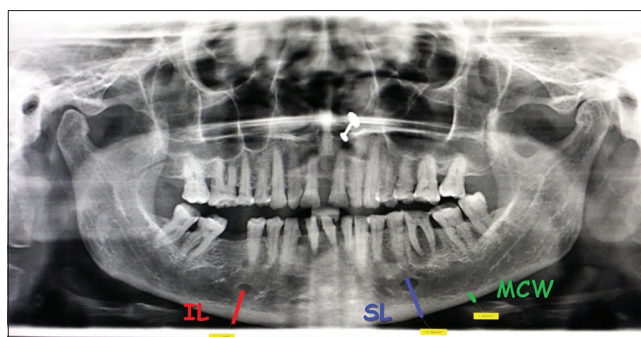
Orthopantomogram showing measurement of SL, IL and mandibular cortical width with the help of Sidexis next-generation software
